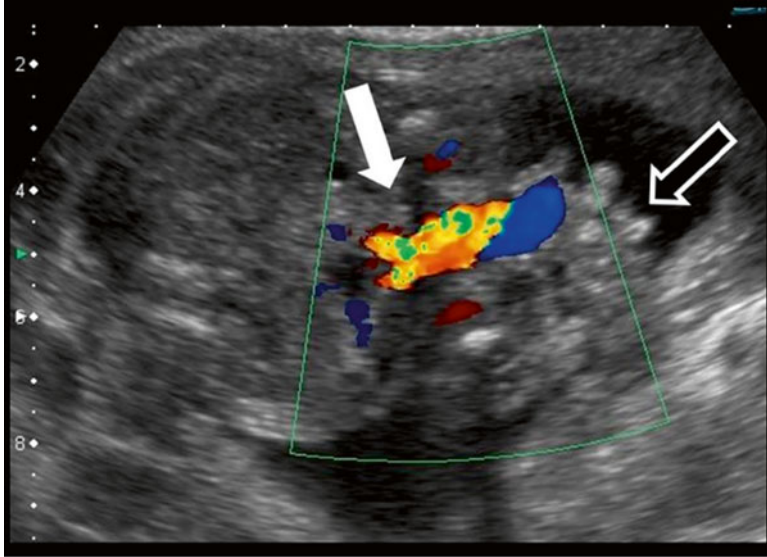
Gastroschisis*: axial ultrasound of a second trimester fetus shows loops of small bowel floating freely in the amniotic cavity (*open arrow*). This is right sided to the normal umbilical cord insertion (*arrow*). Oligohydramnios is present
